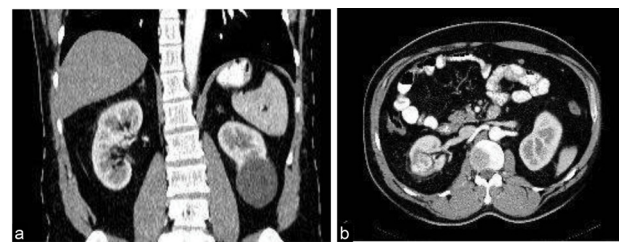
Computed tomography (CT scan) image of hypodense mass of the right kidney in coronal (5a) and axial (5b) view.
